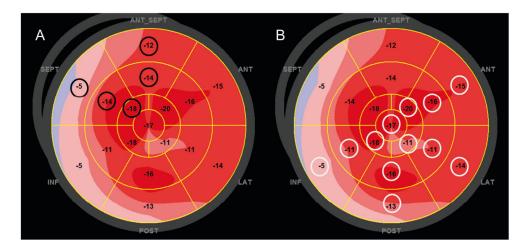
Segmental longitudinal strain analysis. Example of an automatically generated 17 segment "bulls-eye" plot, derived from 2-dimensional speckle tracking echocardiography. Septal strain was calculated as the average of the 5 septal segments (A) and non-septal strain as the average of the remaining 12 segments (B).
